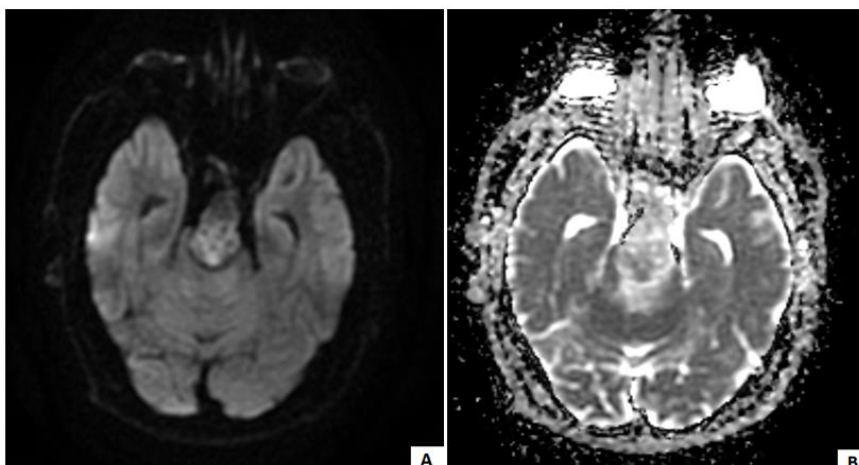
Axial diffusion weighted imaging and ADC images showing non-areas of restricted diffusion within the brainstem Axial DWI sequence, (B) Apparent diffusion coefficient (ADC)
